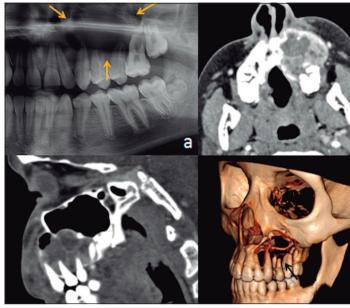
a) Panoramic radiograph showing a large radiolucent and expanding lesion on the left halve of maxillary bone with involvement of 23-24-25 dental roots (arrows). b) CT scan with intravenous contrast: in axial reconstruction it can be identified an heterogenous and expansive lesion in the left posterior maxilla which causes bone remodeliling and erosion. c) CT with intravenous contrast: in sagittal reconstruction (bone window) it can be identified the affectation of dental roots, significant bone thinning and expansion towards the maxillary sinus. d) Volumetric reconstruction showing the lytic lesion that conditions resorption of dental roots (arrows).
